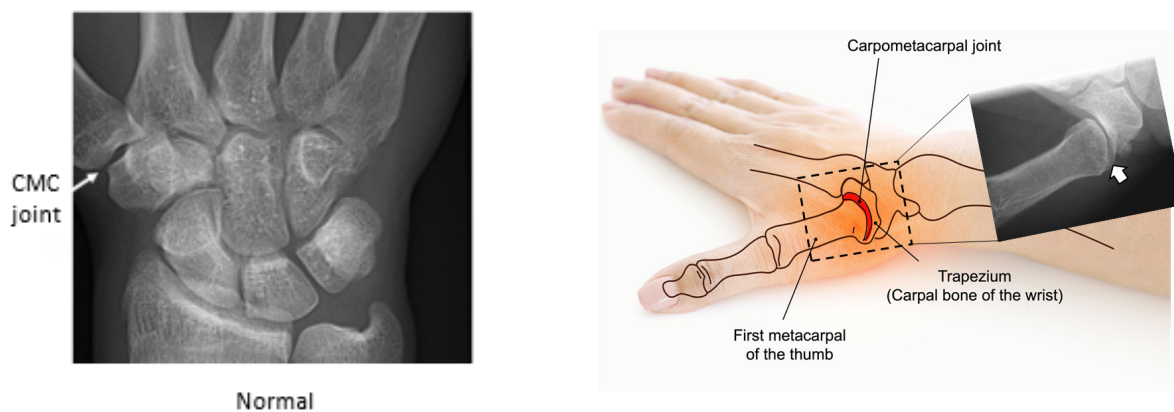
Osteoarthritis at the base of the right thumb CMC joint. X-ray of boxed area shows sclerotic and narrow arthritic joint (white arrow). Image credits left to right: Mikael Häggström, M.D., SrideeStudio
